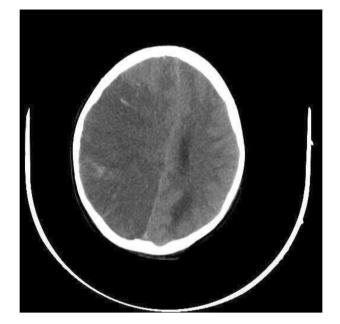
A brain CT scan on the fifth day of admission showed AIS and hemorrhagic transformation in the right MCA and PCA territory after post-COVID-19 Acinetobacter necrotizing superinfection pneumonia.
